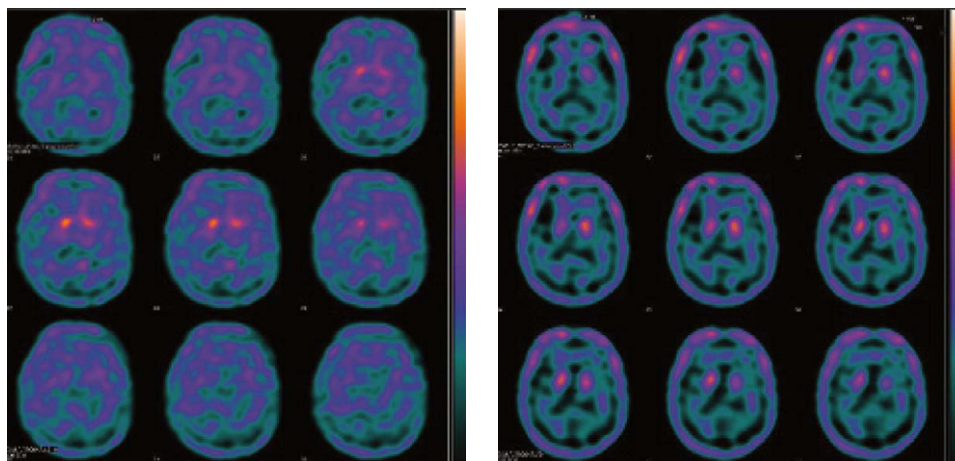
Technetium Tc 99m TRODAT cerebral dopamine transporter single photon emission computed tomography images revealed impairment of uptake in the bilateral basal ganglia regions. The radioactivity uptake in bilateral basal ganglia showed normal caudate but no putamen uptake. The image findings were compatible with parkinsonism.
